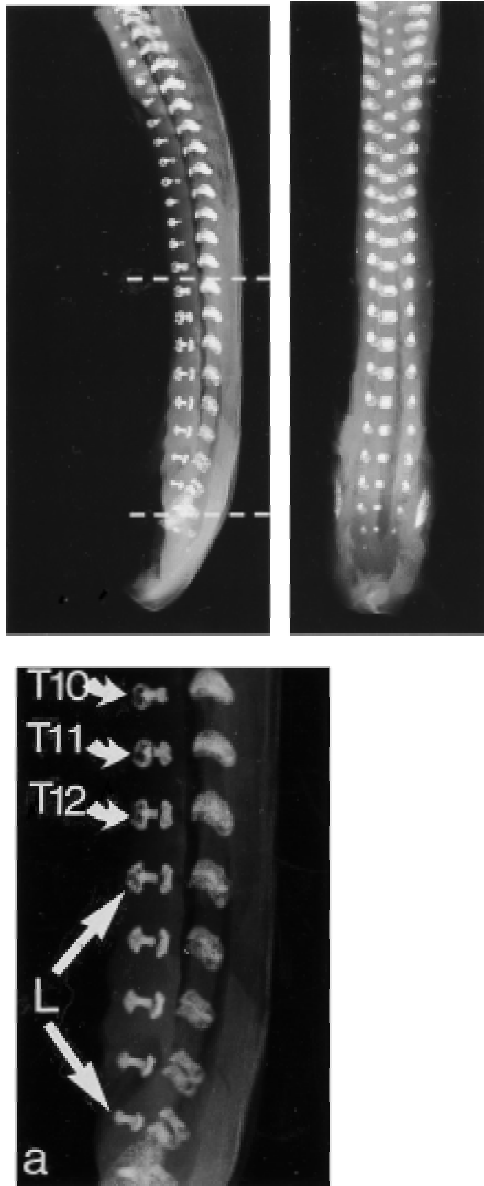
Radiograph of the vertebral column of the axial skeleton in lateral projection (left) and in frontal projection (right) of a human trisomy 13 fetus, gestational age 18 weeks.  $\times 1$ . The segment of the vertebral column between the dotted lines includes the lumbar field. There are malformations of all lumbar vertebral bodies. a: Enlargement of the marked segment of the vertebral column,  $\times 2$ . There is partial clefting of all the vertebral bodies.
